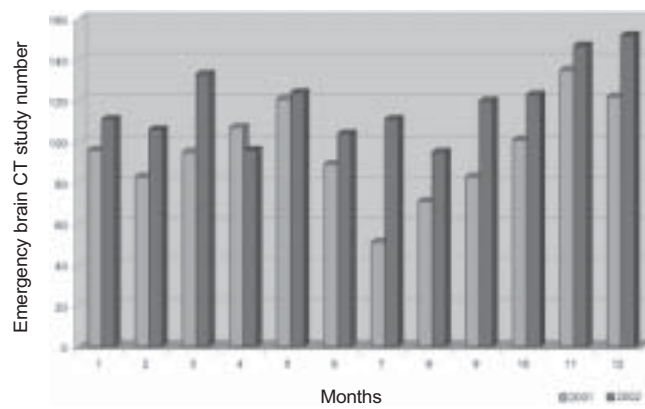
Emergency brain CT examinations during 2001 and 2002.
